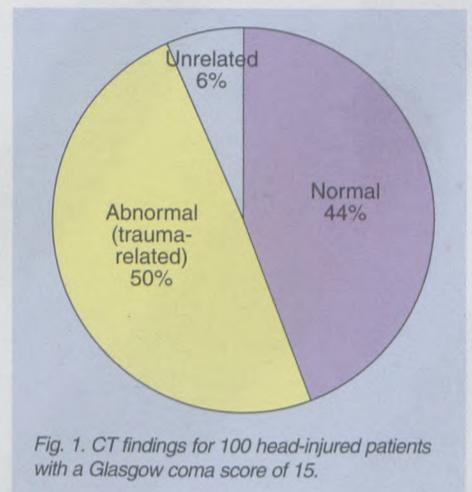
CT findings for 100 head-injured patients with a Glasgow coma score of 15.
